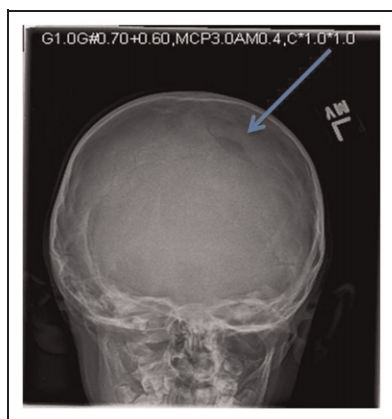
Radiograph revealing well-circumscribed lucent calvarial defect with preserved tapered margins near the vertex.
